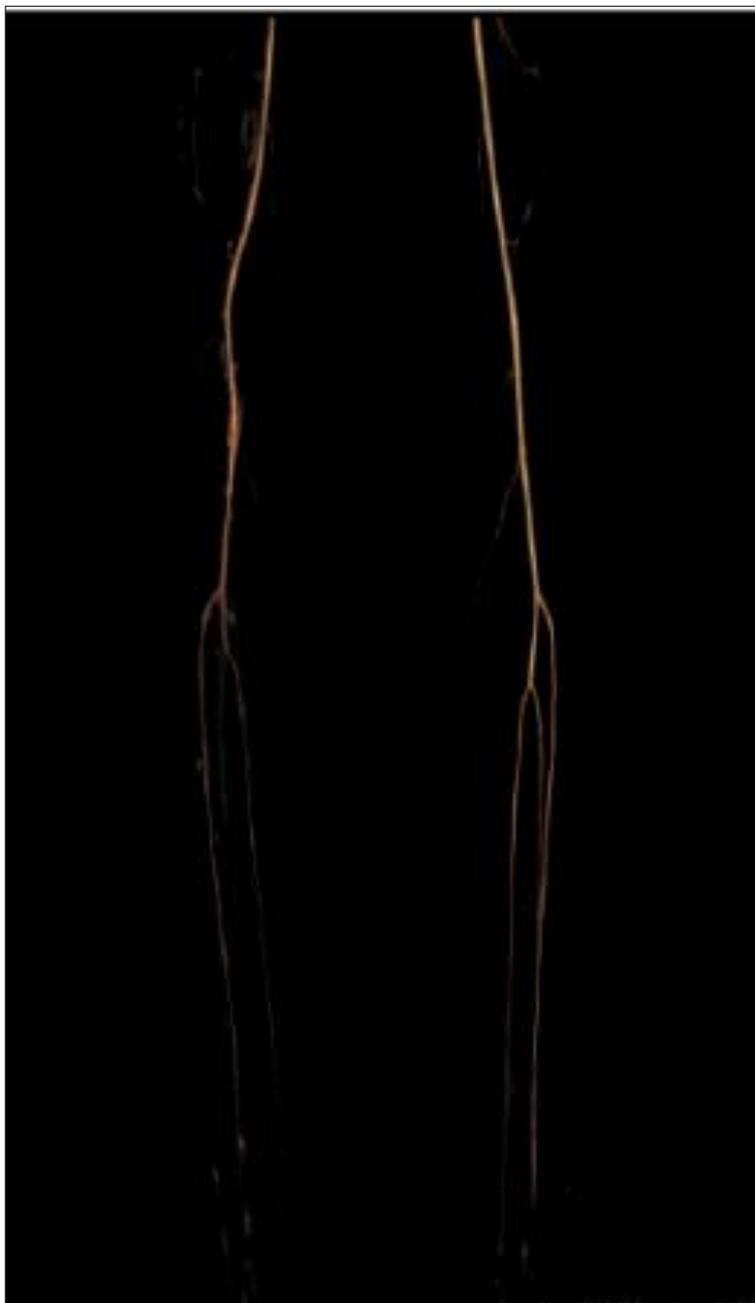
Corresponding CT angiography VR (Volume Rendered) Image showing grade 3 occlusion in right popliteal, tibioperoneal trunk and distal tibial arteries in same patient.
